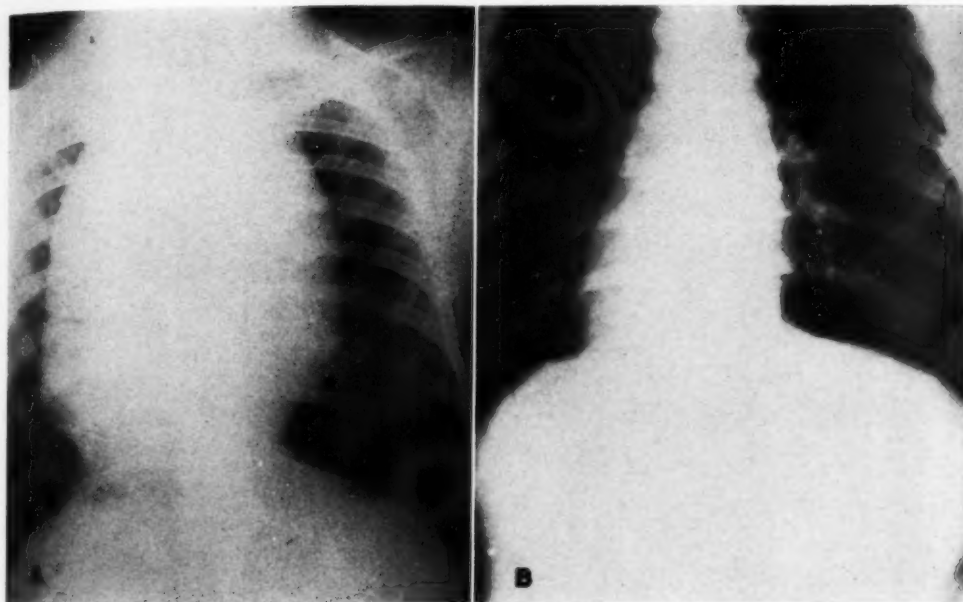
Case I: Mediastinal tumor (leukosarcoma). A. Roentgenogram made March 17. B. Roentgenogram made March 29, ten days after irradiation was begun.
